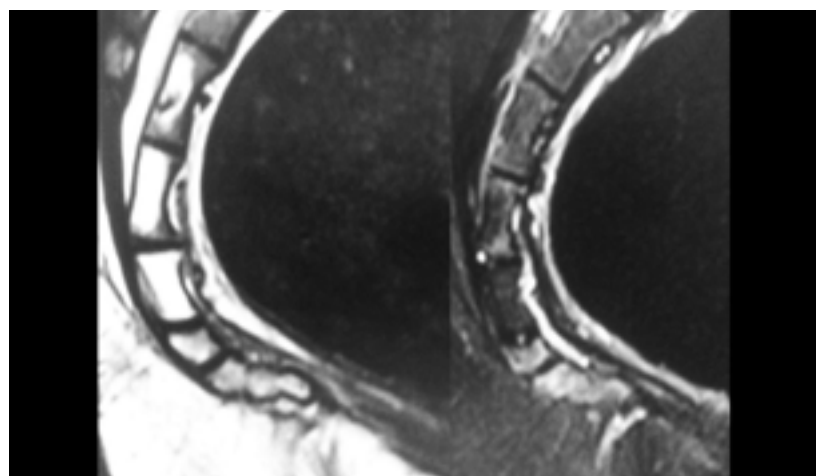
MRI performed X months after a fall in an adult. Sagittal T1 sequence (left) and T2 STIR (right). T2 and also T1 hyperintensity of the last caudal vertebra reflecting inflammatory and haemorrhagic injuries (contusion) of the last two caudal parts.
